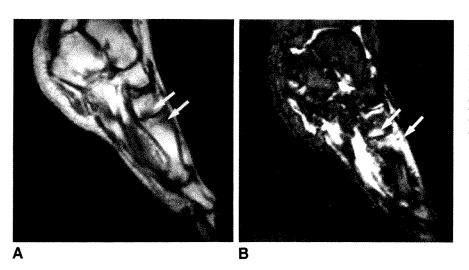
Presumed acute trauma (nonosteomyelitis) in 33-year-old woman. Patient recovered without treatment, and her symptoms were most likely caused by an acute fracture. Abnormal signal is shown at metatarsal head and cuboid (arrows) on both T1-weighted (683/20) (A) and short-tau inversion recovery (STIR) (2416/150) (B) images. MR findings of this patient cannot be differentiated from those of osteomyelitis. Small joint effusion can also be seen on STIR image (B).
